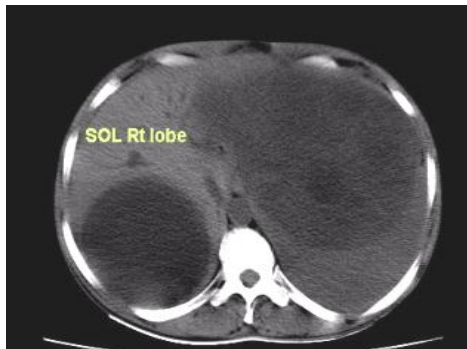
CT Scan-Septate tumour & SOL Rt lobe liver
